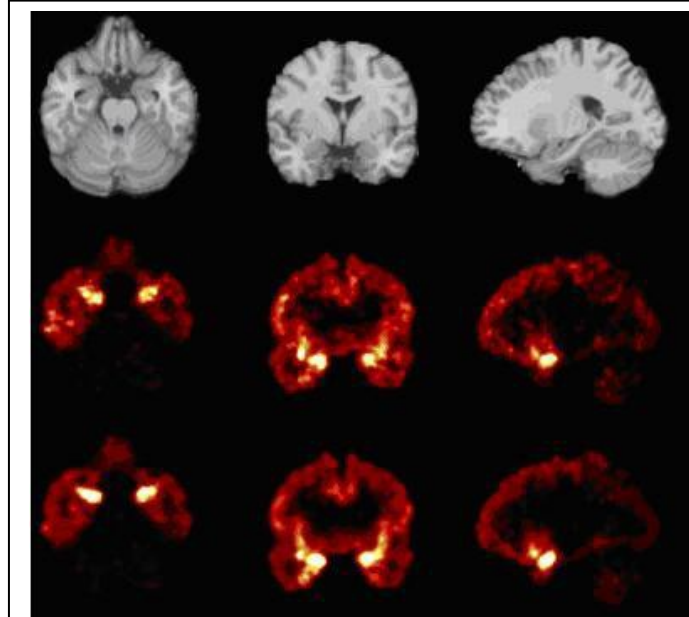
Top row: MRI images (axial, coronal, sagittal) of individual subject. Middle row: Corresponding BP_{ND} images estimated using SRTM. Bottom: Corresponding BP_{ND} images estimated using SRTM2. They are slightly less noisy than SRTM, as would be expected.
